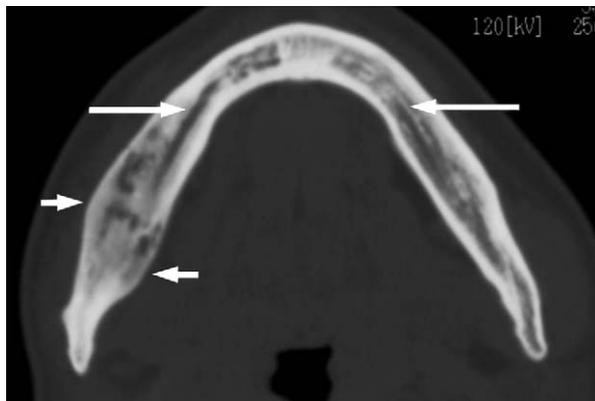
An axial CT image of mandibular osteomyelitis in SAPHO syndrome at the level of mandibular canals (*long arrows*) shows the enlargement of the left mandible (*short arrows*).
